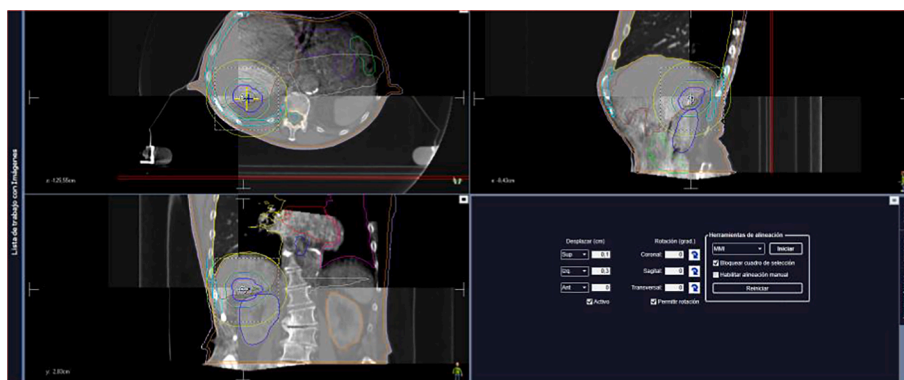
CBCT showing the displacements with hepatic contour guide.
